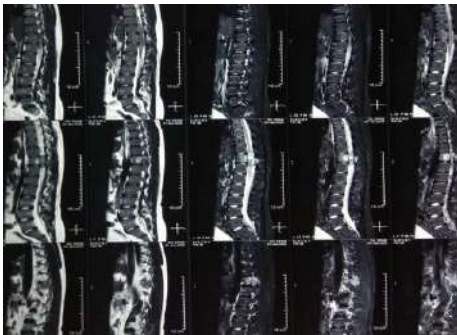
MRI D-L Spine (Sagittal)
